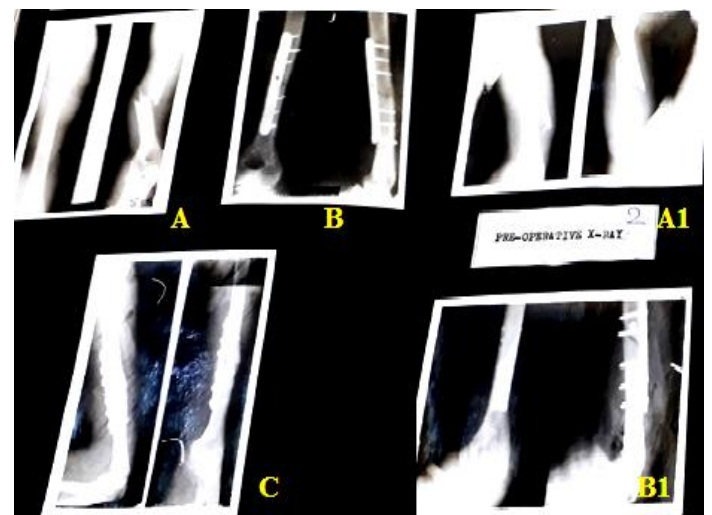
Diaphyseal fractures radiographs: A, A1- pre-operative, B, B1- post-operative, C- union after plate fixation
